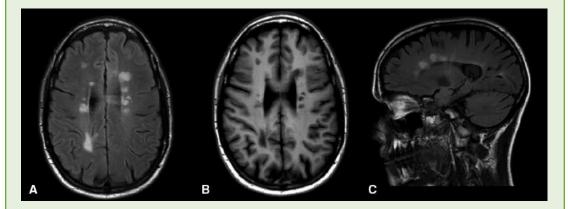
Multiple sclerosis. A. Characteristic white matter lesions of multiple sclerosis depicted on an axial FLAIR image. B. Low signal intensity of the lesions on T1-weighted images suggests chronic lesions. C. Sagittal FLAIR image depicts the radial orientation of white matter lesions characteristic of multiple sclerosis. (From Louis ED, Mayer SA, Rowland LP. Merritt's Neurology. 13th ed. Baltimore: Lippincott Williams & Wilkins, 2015; Fig. 21-6, with permission.)
